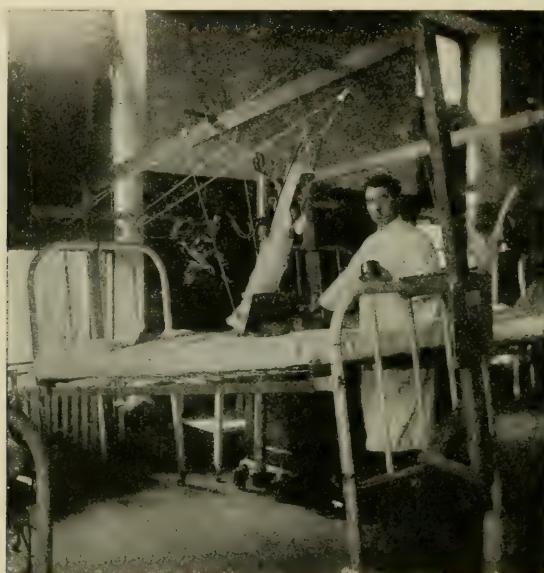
Roentgenologist making a bedside exposure. Plates taken in two planes are required. The portable *x-ray* is the most important factor in controlling the angle of the splint, the amount of weight used for traction, and the correction necessary for the best results. (Speed.)
